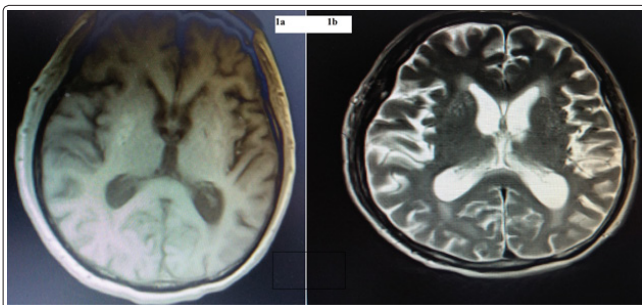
MRI of brain after two episodes of chorea. Figure 1a: after the first episode, MRI showed high signal intensity on T1-weighted and low signal intensity on T2-weighted images on bilateral basal
